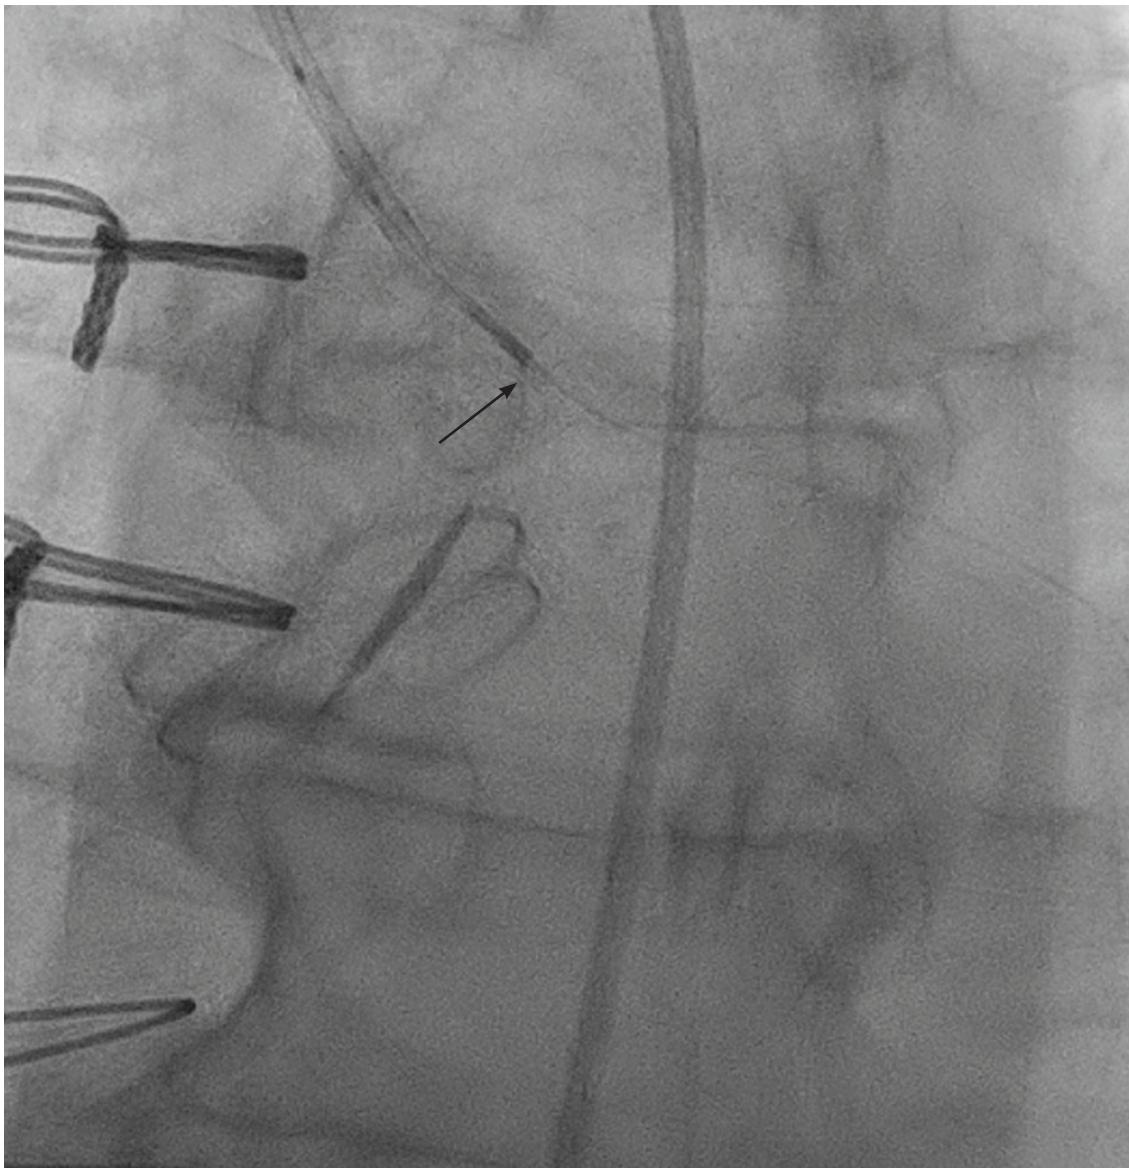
Marking the ostium of the left main on the intravascular ultrasound in the left anterior oblique 18-degree view.
